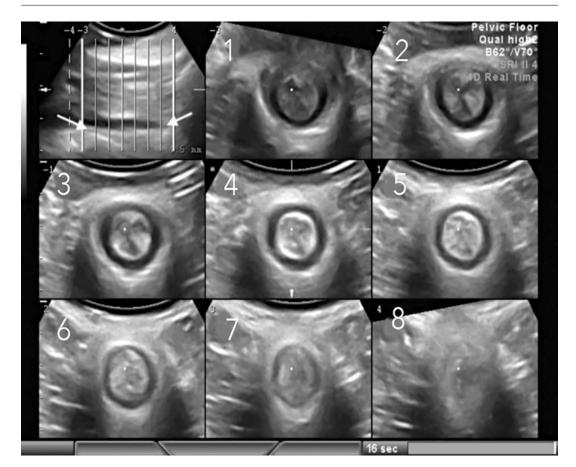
Tomographic ultrasound showing an uninjured sphincter. The location of eight coronal slices is shown in the midsagittal reference plane in the top left hand corner.
